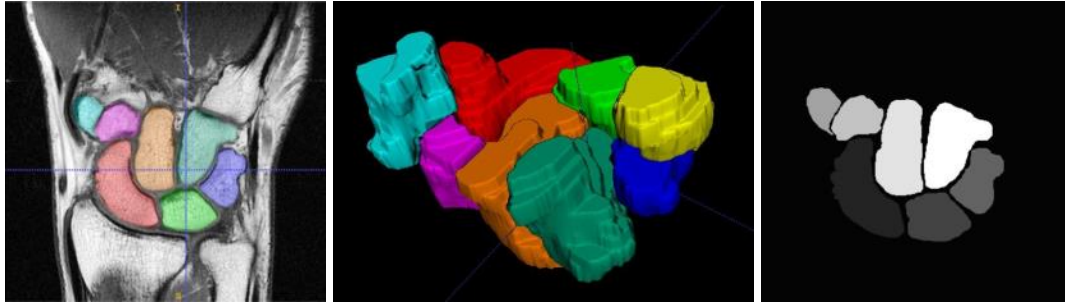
Manual carpal bone segmentation of T1-weighted eMRI of the right wrist. The MR image with segmentation overlay (left). A 3-D rendering of the segmentation (centre) and the grayscale label field (right).
